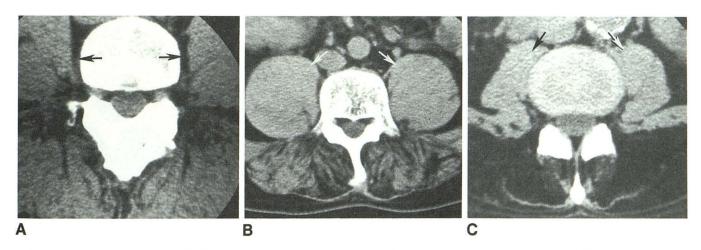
CT scans in patients with McArdle's disease. Note sparing of psoas muscles in all three patients (arrows) associated with various grades of posterior paraspinal muscle atrophy.
